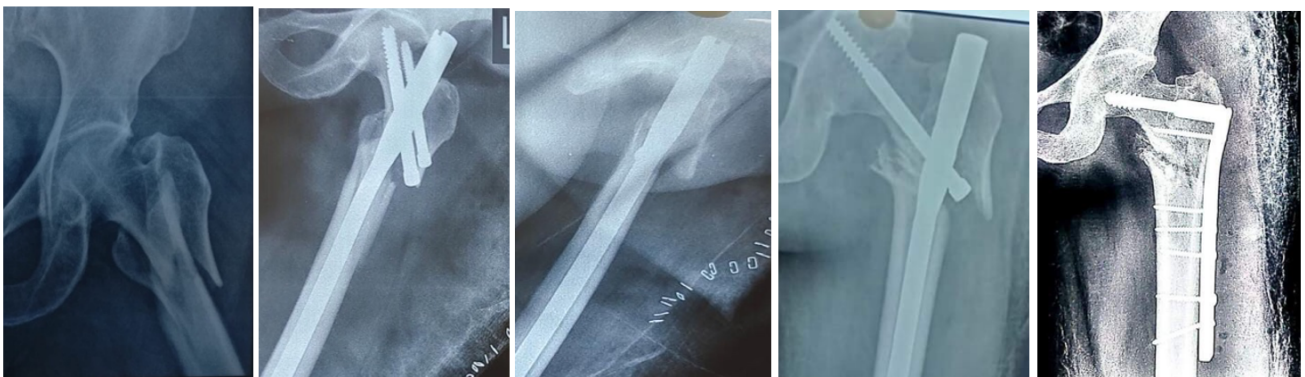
Failed fixation case 2. AO type A3. 1 fracture fixed with long PFN, Immediate post op X-rays show a total stability score of 5. Weight bearing lead to reverse z effect with derotation screw back out and principle screw penetration into hip joint. Initially derotation screw was removed, followed by revision surgery with implant removal and ORIF + DCS
